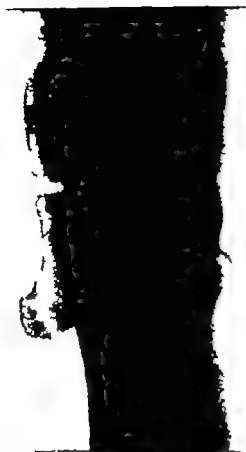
(No. 35720) Roentgenogram showing a typical exostosis in the upper end of the tibia near the insertion of the quadriceps tendon. The outgrowth is continuous with the normal bone beneath and a distinct bursa overlies the exostosis. The presence of a calcareous buritis makes this complication clearly visible. This is the exostosis bursata of the older authors.
